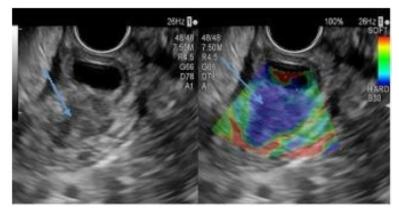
Upper endoscopic ultrasound. Distal cholangiocarcinoma. On the left, a dilated distal common bile duct and a hypoechoic tumoral mass (blue arrow) can be seen. On the right is an image of the elastography examination with the tumoral mass colored in blue (hard tissue) (blue arrow).
